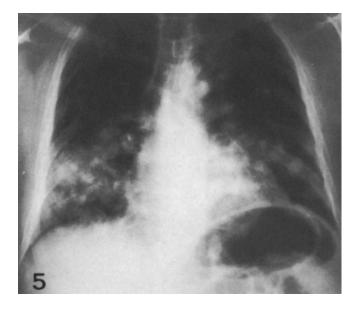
Case 2. Chest X-ray: shows bilateral basal nodular pulmonary infiltrates with confluence in the right hung
